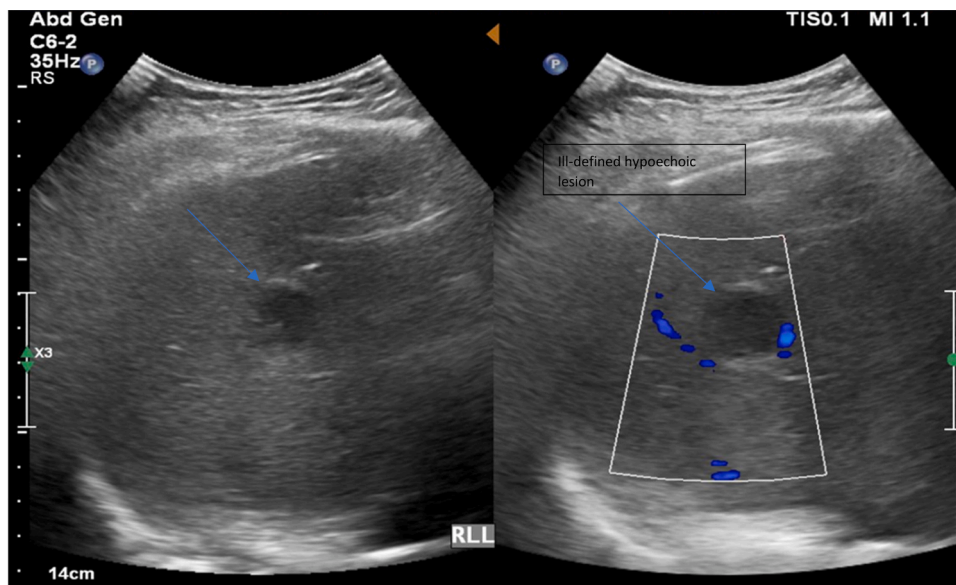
Liver ultrasound showing an ill-defined hypoechoic focal lesion in the right liver lobe.
